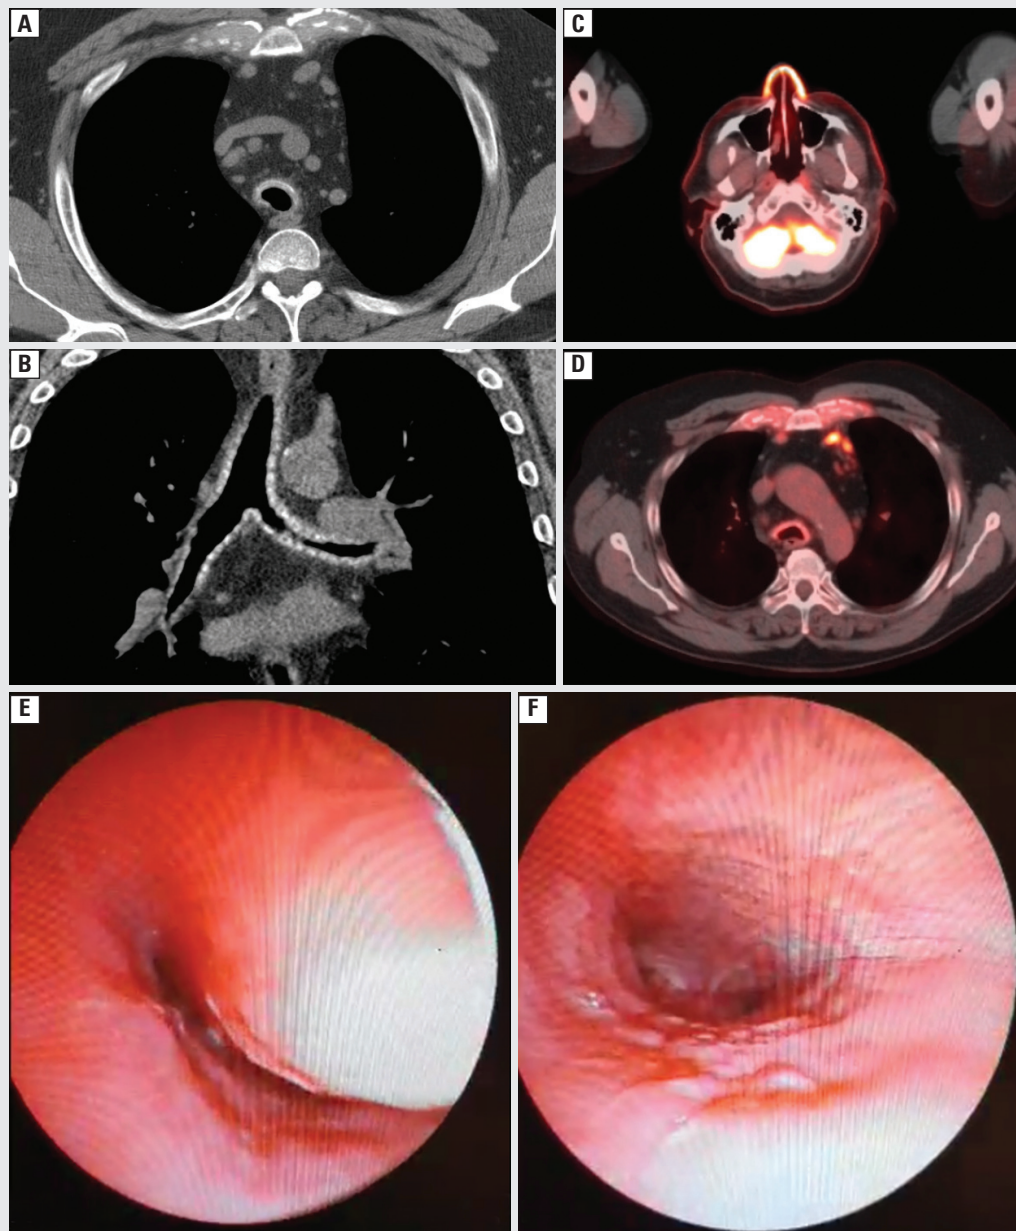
Chest computed tomography showing thickening and calcification of tracheal (A) and bronchial cartilage (B). Positron emission tomography showing fluorodeoxyglucose (FDG) captation of the nasal cartilage (C) and FDG captation of costal and tracheal cartilage (D). Bronchoscopy revealing tracheobronchomalacia (E) and thickened tracheal mucosa with cobblestone appearance (F)
